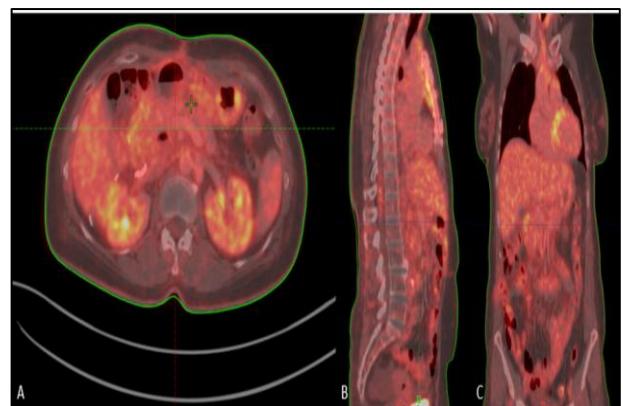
Follow up PET CT scan at 3 months (showing no abnormal FDG uptake): A) axial images; B) sagittal images; C) coronal images.
